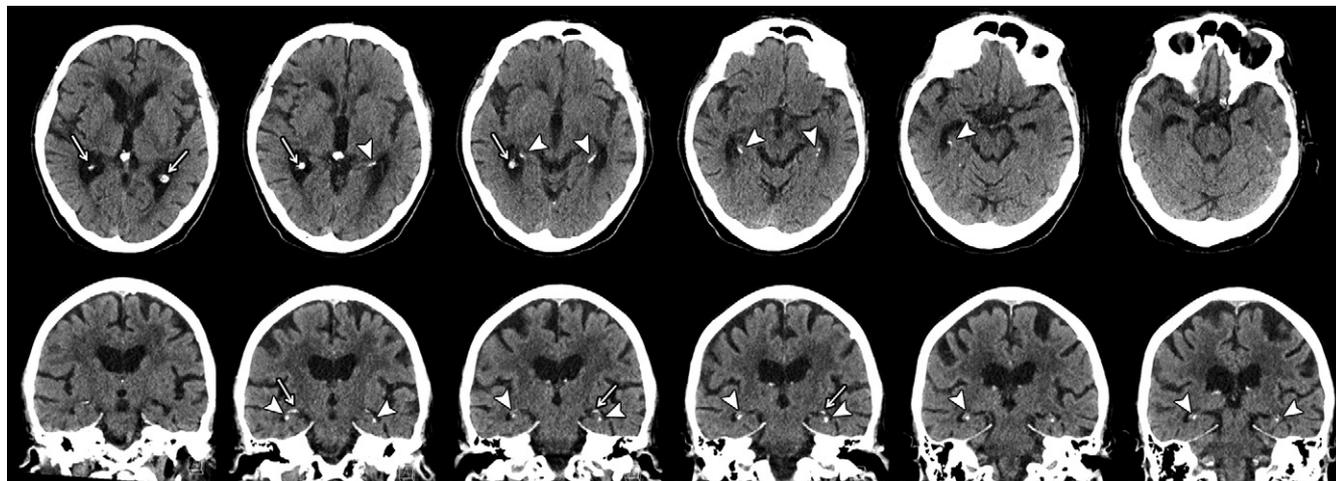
Axial and coronal CT images in 76-year-old man show severe hippocampal calcifications (arrowheads). Arrows indicate calcifications of choroid plexus.
